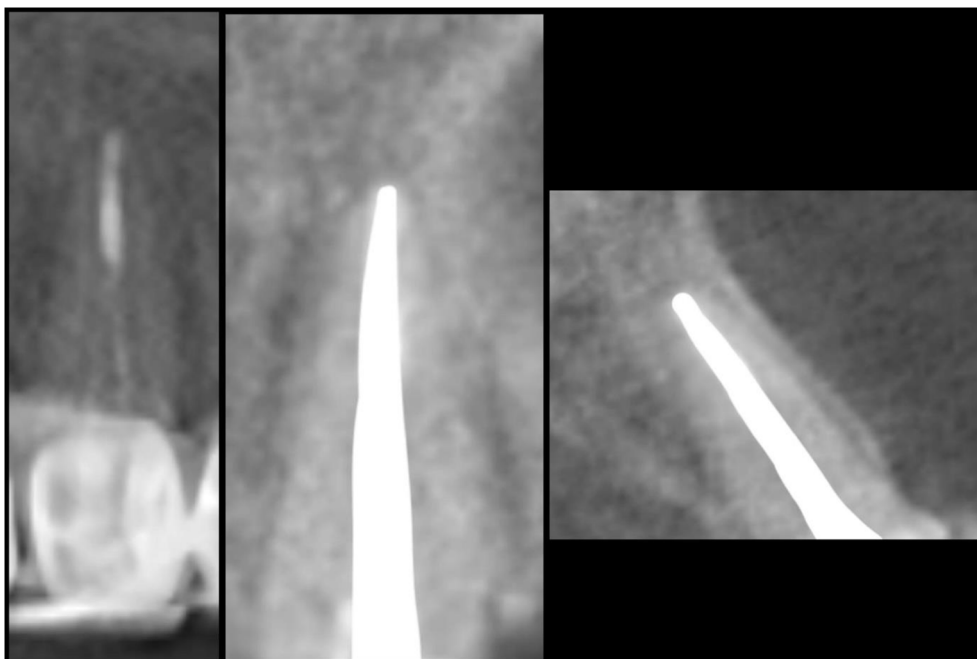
An example of a tooth with a fiber intra-radicular post without a periapical radiolucent lesion (coronal and sagittal)
